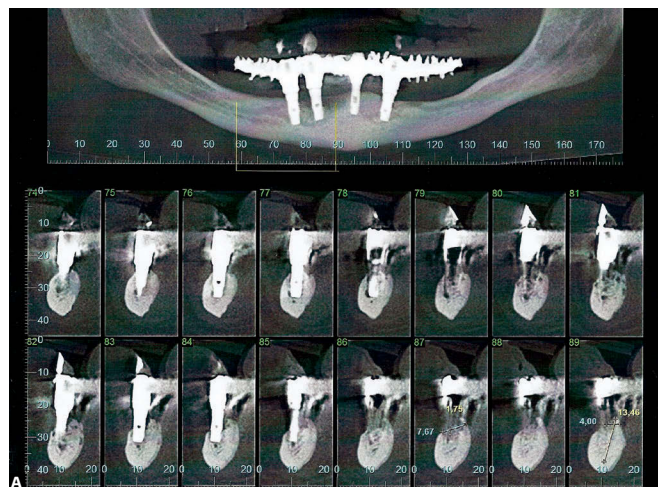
Panoramic radiograph revealing four implants placed and in masticatory function.
